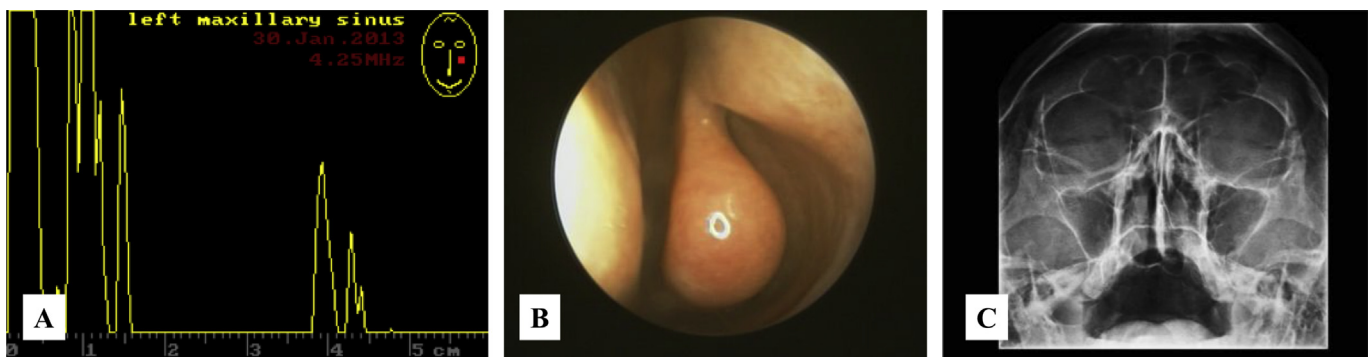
A 77-year-old female patient with symptoms of rhinosinusitis for 1 day. (A) Sinus ultrasound detected fluid in left maxillary sinus, but (B) rigid nasal endoscope and (C) plain film had no evidence of maxillary sinusitis. Endoscope still has limitations and ultrasound could be a complementary tool for diagnosing acute maxillary sinusitis.
